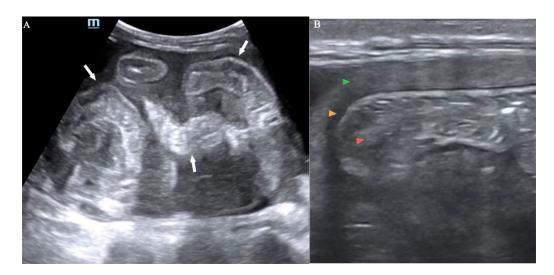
B-mode low (A) and high (B) frequency abdominal ultrasound scans: A shows centrally clumped up bowel loops (white arrows in A) and ascites fluid. A markedly thickened membrane (green arrowhead), bowel wall (yellow arrowhead), and bowel interface (red arrowhead) giving a trilaminar appearance are shown in B. Note the barely resolved outline of the membrane, the peritoneum, and the bowel wall, which tend to merge with each other.
